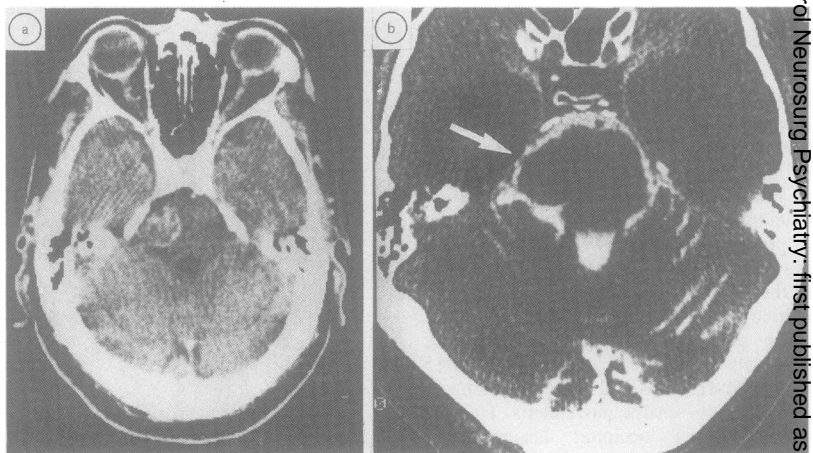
Fig a CT: after contrast enhancement. Shows oval well-defined lesion in the side of the brain-stem. b CT: with intrathecal contrast. Tumour (arrowed) is shown to be extrinsic to the brain-stem.
